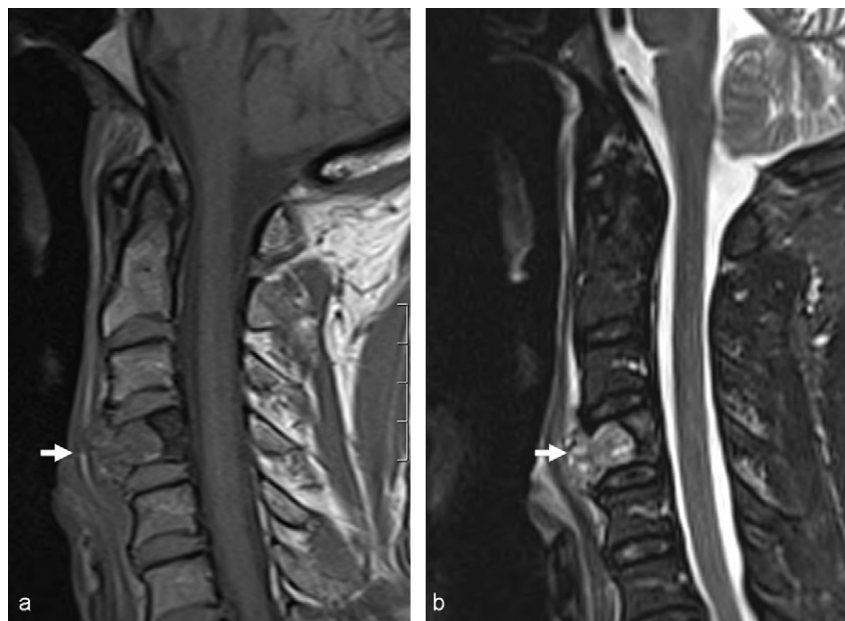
(a–b): A sagittal MRI (T1(2a) and T2(2b)) performed on the same patient demonstrates the ventral C4 lesion again where it can be seen destroying the ventral elements and extending to the retropharyngeal region (arrows). No compromise of the spinal canal or spinal cord compression is noted.
